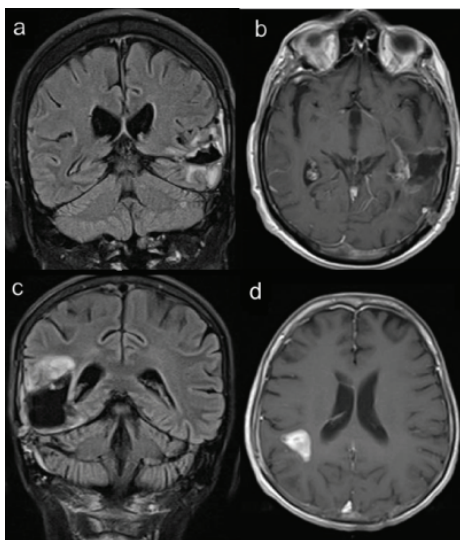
FLAIR and post-contrast T1W images obtained in the 10th week after surgery in the patients with true progression (upper row) and pseudoprogression (lower row). Although minute area of post-contrast enhancement was observed in b) and d) pseudoprogression (PSP) and radiation and chemotherapy (RCT). In case of pseudoprogression follow-up, the magnetic resonance imaging (MRI) demonstrated a decrease of region of post-contrast enhancement in both entities [a), c)].
